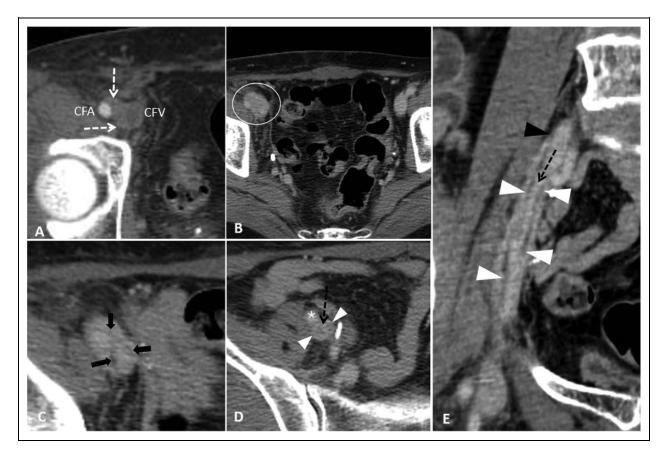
Computed tomography angiogram (CTA) of an iliofemoral vein dissection. A, On arterial phase, a subtle hematoma (white-dotted arrow) was seen between the right CFA and the CFV. B, On venous phase, the vein wall was extensively and irregularly thickened compared to the contralateral side. Note the presence of acute intraluminal thrombi (circle). C, Black arrows indicating the entry site of dissection into bilateral wall of the CFV. D, E, The true lumen (black-dotted arrow) was encircled between the thrombosed false lumens (white arrowhead) and markedly collapsed. Asterisk indicates the CFA. Black arrowhead indicates the dissection closure at the level of the common iliac vein. CFA indicates common femoral artery; CFV, common femoral vein.
